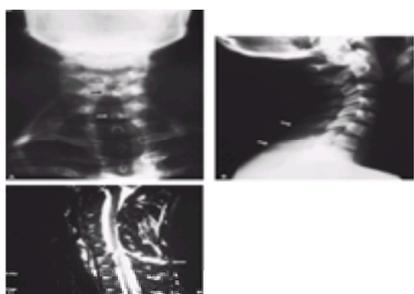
Hyperflexion sprain. A: Cervical spine radiograph, anteroposterior view, evidences widening between the spinous processes of C-6 and C-7 (arrows). B: Cervical spine radiograph, lateral view, evidences widening between the spinous processes of C-6 and C-7 (arrows), slight anterolisthesis of C-6 on C-7 with kyphotic angulation of C-6 relative to C-7. C: Magnetic resonance imaging, sagittal short-time inversion recovery images, evidences high signal of C-6 to C-7 interspinous process ligament (arrow) secondary to disruption of the interspinous process ligament and ventral dural indentation at C-6 to C-7 and C-7 to T-1 caused by disk protrusion, epidural hemorrhage, or both. There is increased signal in the spinal cord at the C-6 to C-7 consistent with a spinal cord contusion.
